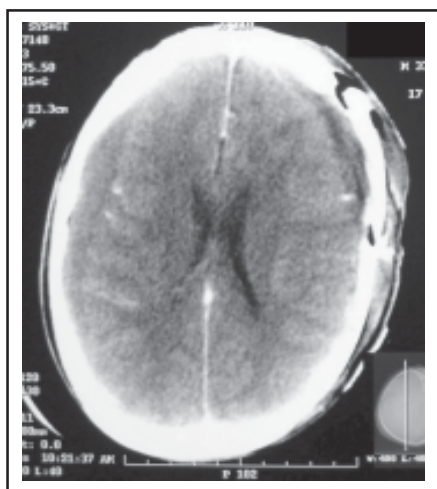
Postoperative contrast CT scan showing resolving left sided haematoma and persisting collection on right side however mass effect and cerebral oedema is reduced.
